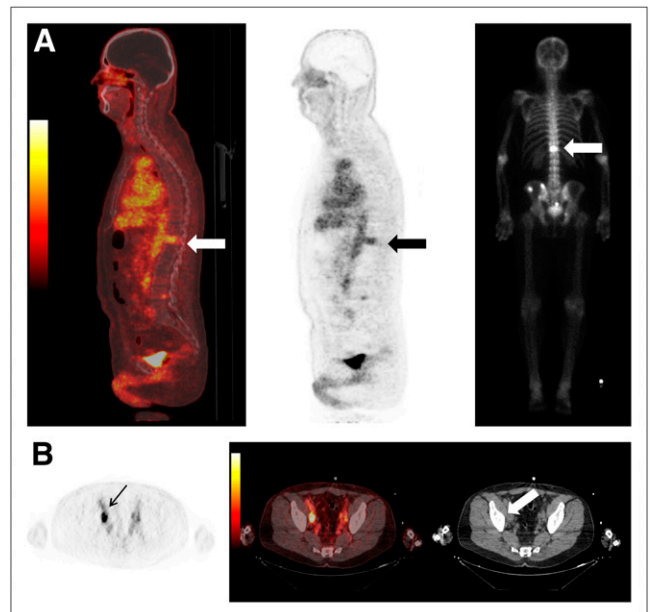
Examples of concordant findings on ^{18}F -DCFBC PET and CIM: (A) T12 bone metastasis (arrows) seen on bone scan (far right) and (B) retroperitoneal right external iliac LN (arrow) seen on CT (arrow).
